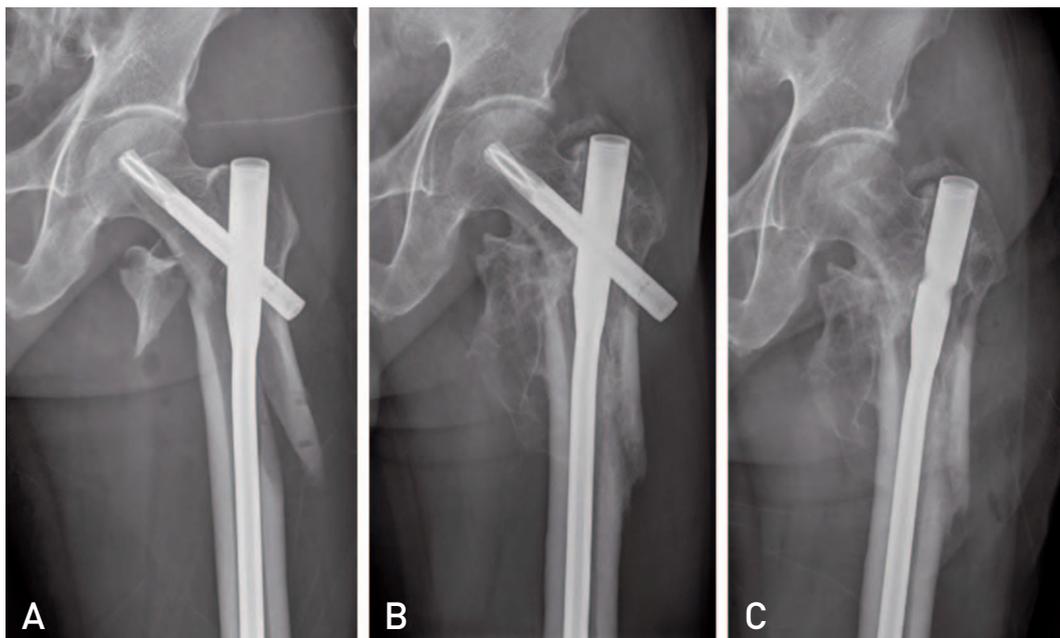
Seventy three year old male patient complained lateral aspect pain at the left lateral position. (A) Immediate postoperative radiographs. (B) One year after operation radiograph that shows sliding of helical blade screw. (C) Helical blade screw was removed due to sustained discomforts and pain on the trochanteric region.
